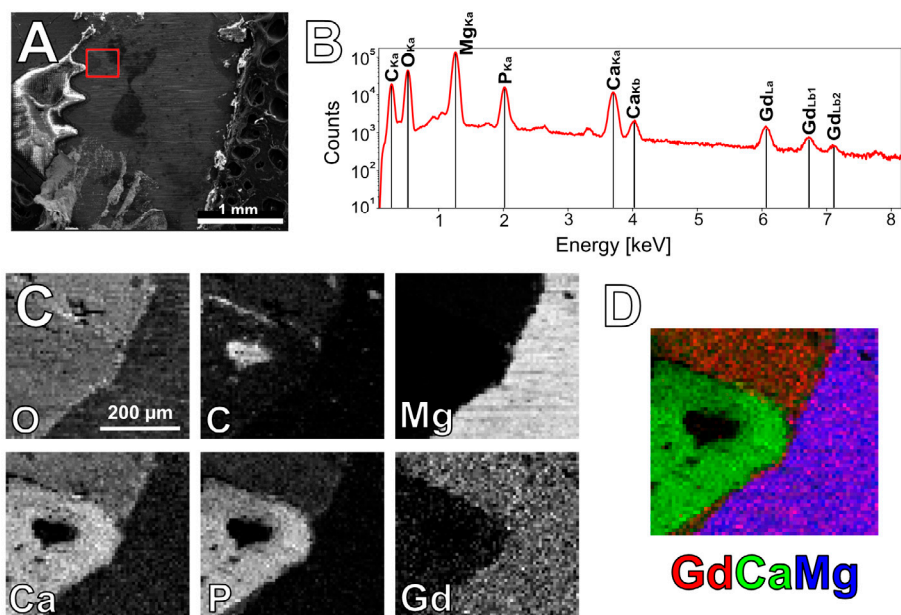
Example of x-ray elemental mapping.
